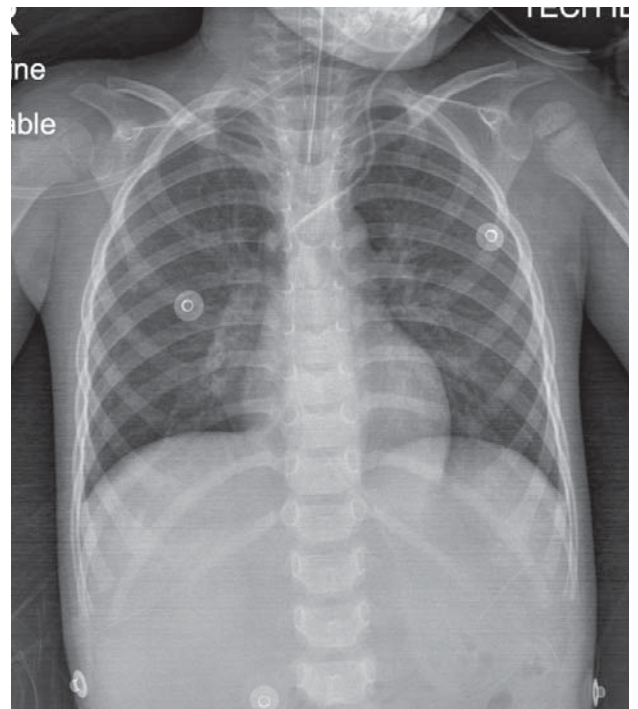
On January 27, 2013 at 5:30, a chest x-ray AP supine position and post removal ECMO reveals heart and lung appear normal.
